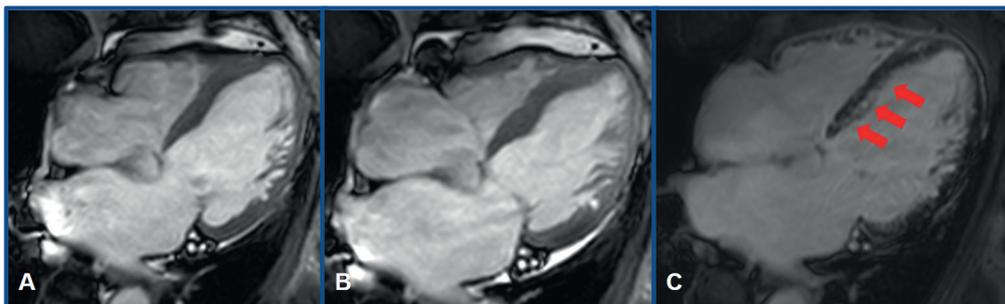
Nuclear MRI: Severe impairment of left ventricular systolic function (LV ejection fraction 25%) due to global hypokinesia. Panel 4A shows the heart at the end of diastole, and panel 4B shows it at the end of systole. Late gadolinium enhancement sequences (panel 4C) reveal subendocardial enhancement in the basal and medial septal segments, consistent with myocardial fibrosis, indicated by the three red arrows. Fibrosis is likely related to hypereosinophilia, although an ischemic origin cannot be entirely ruled out.
